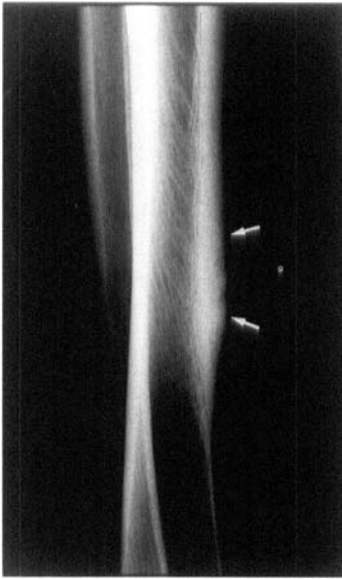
Periosteal osteosarcoma. Radiographs reveal thickness of cortical bone with saucer-like osteolysis (white arrows), without involvement of marrow.
